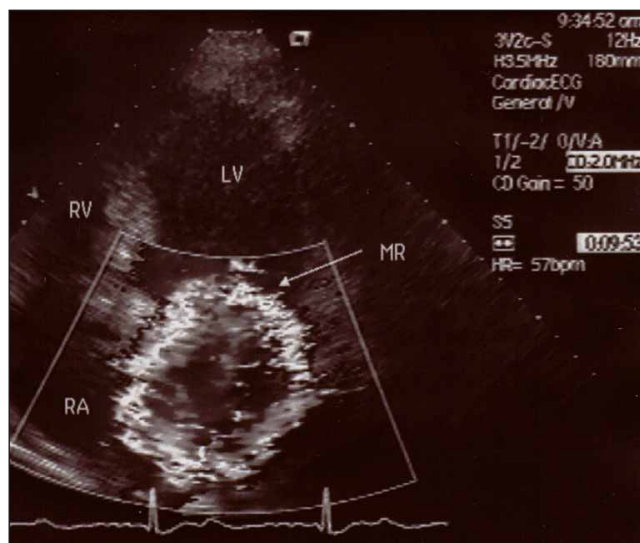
Transthoracic echocardiography – severe mitral regurgitation.
